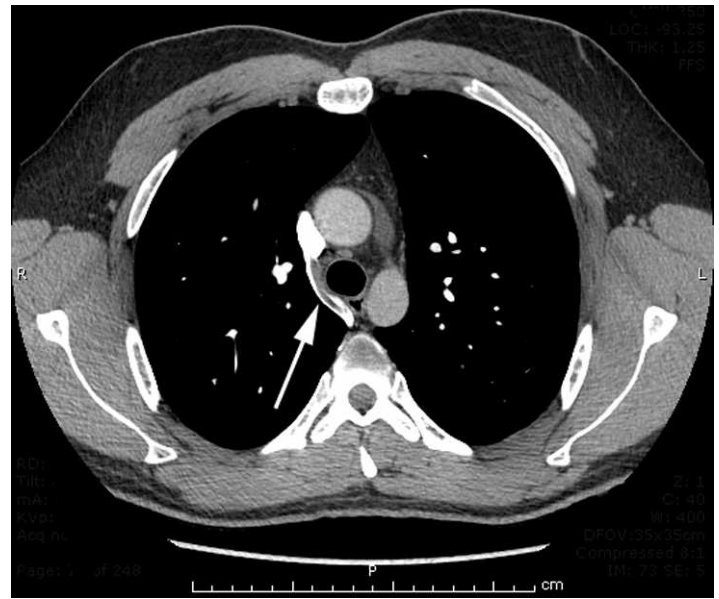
Axial section from the computed tomographic pulmonary angiogram showing a thrombus in the azygos vein (arrow).
